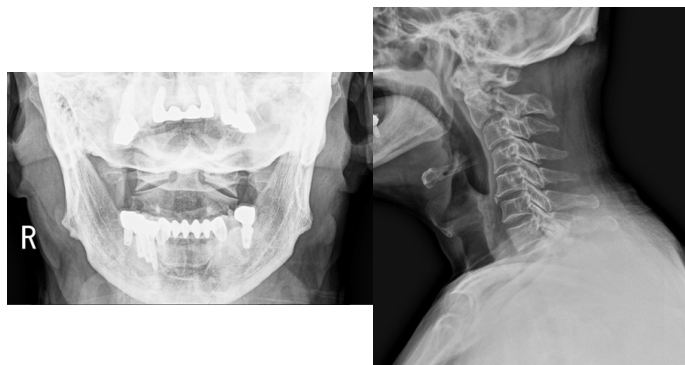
Plain film radiograph (open-mouth view) demonstrating no bony abnormalities. However, plain film radiography (lateral view) shows a fracture of the C2 pars interarticularis with angulation and translation of C2-C3.
